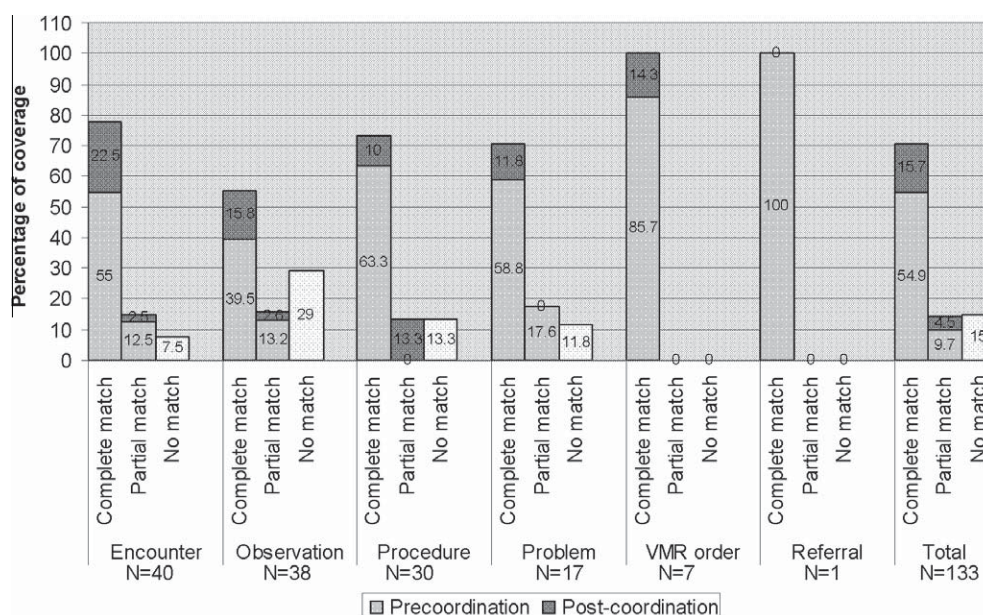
Content coverage of SNOMED CT based on VMR classes.
